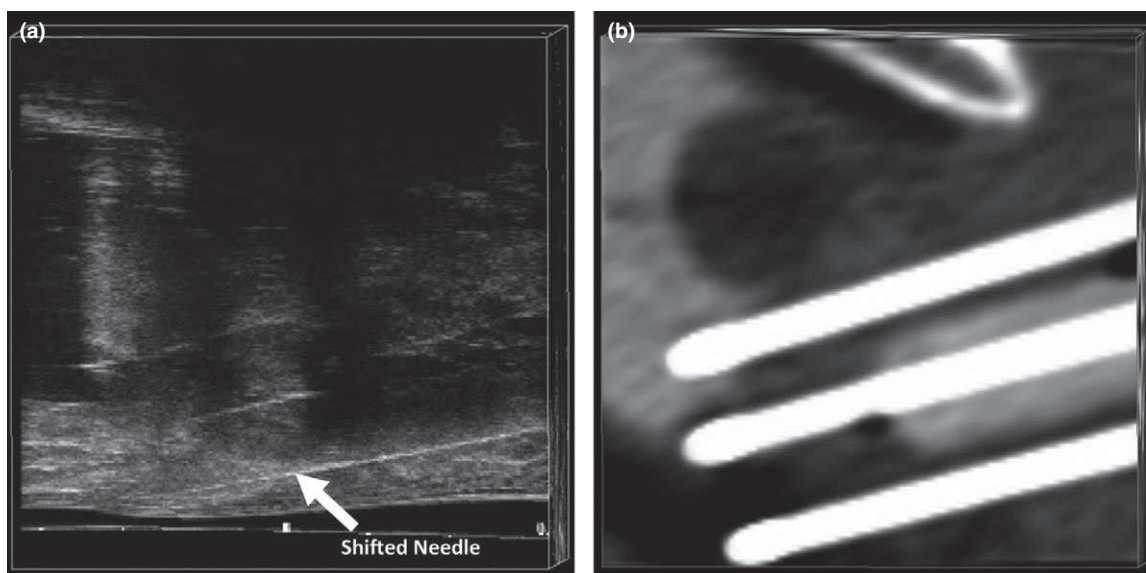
(a) 3D TRUS patient image with needle shifted anteriorly due to probe pressure indicated. (b) Rigidly registered patient CT image showing the bottom-most needle in the unshifted position.
